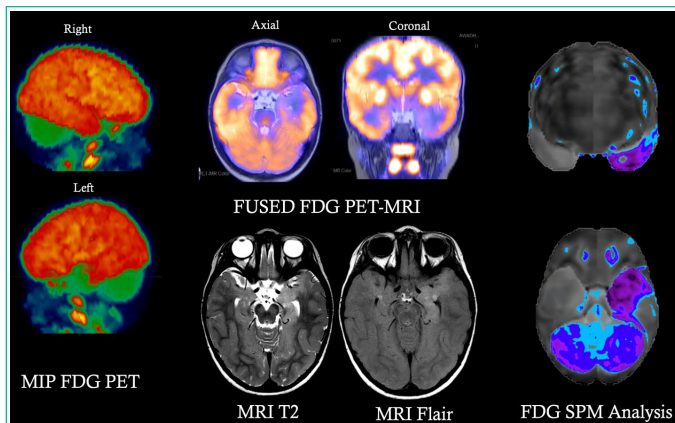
An FDG PET/MRI co-registered scan for an epilepsy patient showing a well-defined area of focal hypometabolism.
